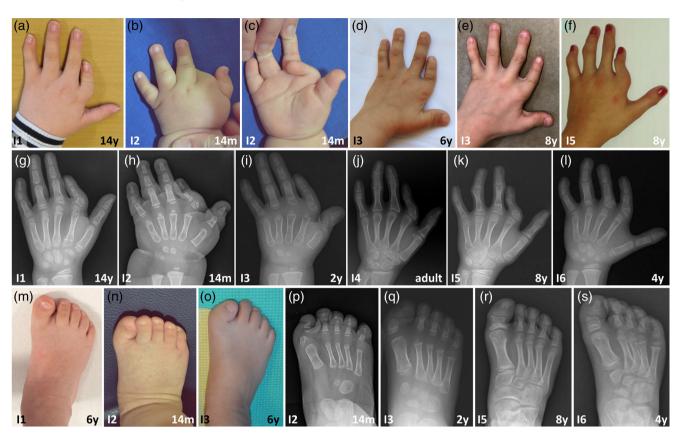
Hand/feet photographs and radiographs. (a–f) Photographs of the hands of individuals (l) 1, 2, 3 and 5 at different ages, showing short and small index fingers with ulnar deviation and spontaneously flexed position of the metacarpophalangeal joint, especially in I2. Note that there is also shortening of the other fingers, especially the middle fingers, and ulnar deviation of all fingers. Photographs of the hands of I3 display additional flexed position of the first metacarpophalangeal joint. (g–l) Hand radiographs of I1-6 at different ages, showing triangular shaped bones in the second metacarpophalangeal joints. In I1-3, 5 and 6 the triangular bone has lateral growth plates, whereas in I4, it is fused with the proximal phalanx. In I3, 5 and 6, the third and fourth fingers are also affected. The phalanges of the index finger are small and/or short, and the index fingers are ulnarly deviated. There is also ulnar deviation and shortening of other fingers in all individuals. Clinodactyly of the fifth finger and short middle phalanges can be found in most individuals. In I3, the proximal phalanx of the first finger is ulnarly deviated and has an abnormally shaped growth plate. A detailed description of the radiographs can be found in the Supporting Information. (m–o) Photographs of the feet of I1, 2 and 3 showing short first toes and hallux valgus. (p–s) Radiographs of the feet of I2, 3, 5 and 6, showing short proximal phalanges and hallux valgus [Color figure can be viewed at wileyonlinelibrary.com]
